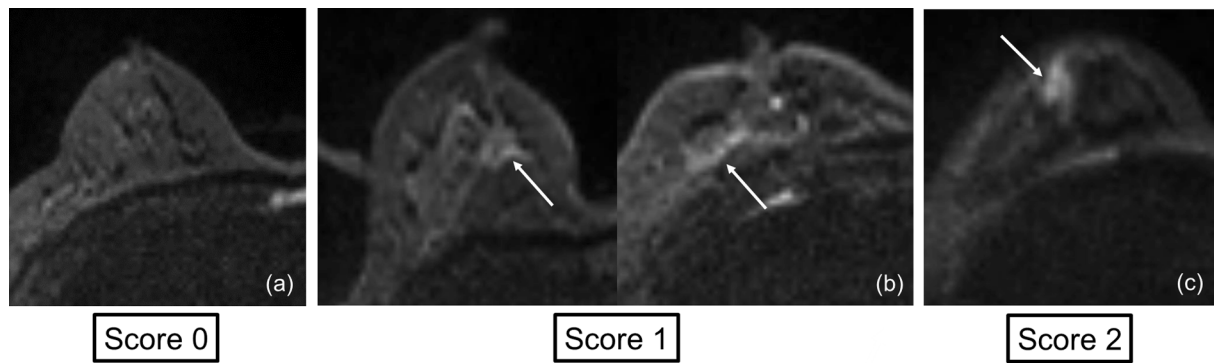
DWI scores. DWI of the target lesion was evaluated and scored using a three-point scale. (a) Score 0: no abnormal signal intensity. (b) Score 1: intermediate signal intensity in a faint scar-like shape (arrows). (c) Score 2: obvious high signal intensity (arrow). No lesion sizes were included in the scoring method.
